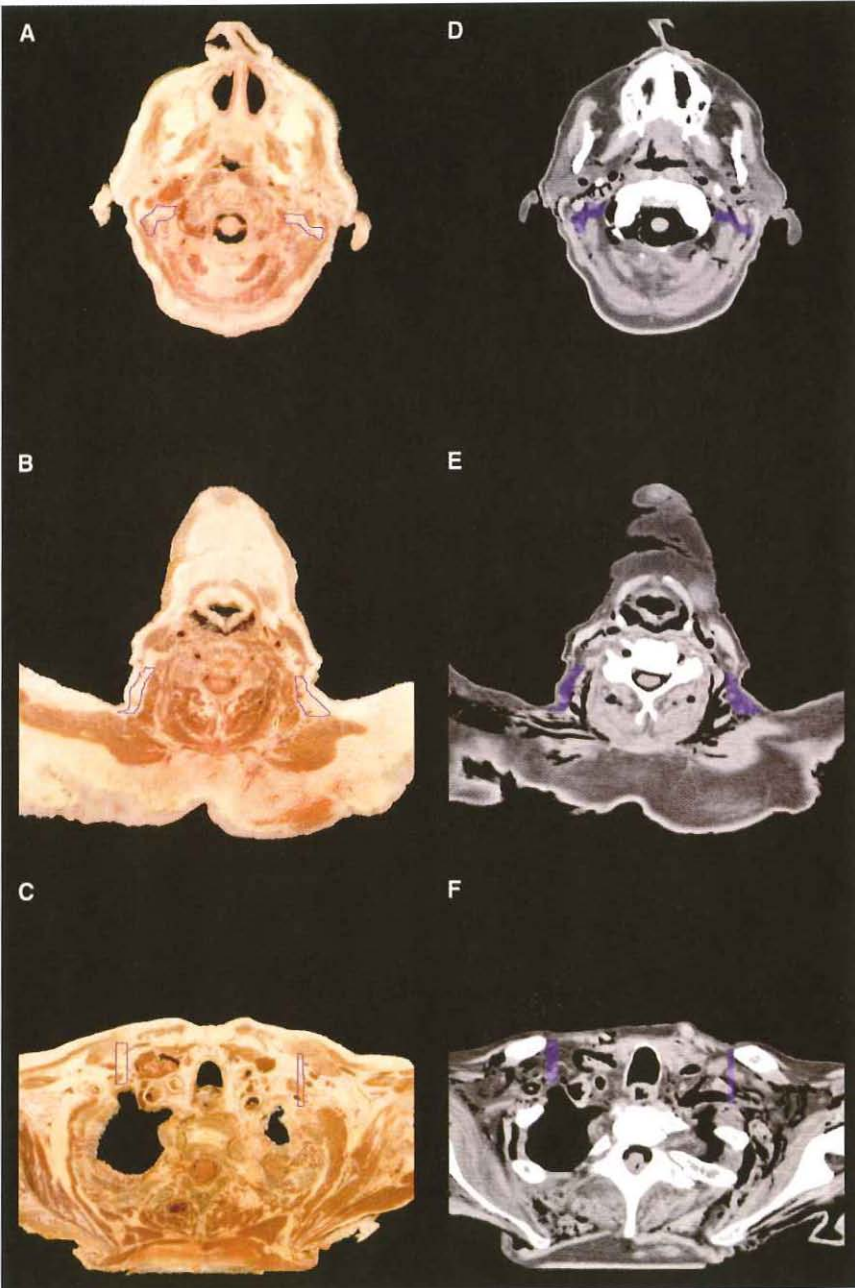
Region 5: borders are in blue outline on the anatomy slices (left) and in blue colorwash on the CT slices (right).
